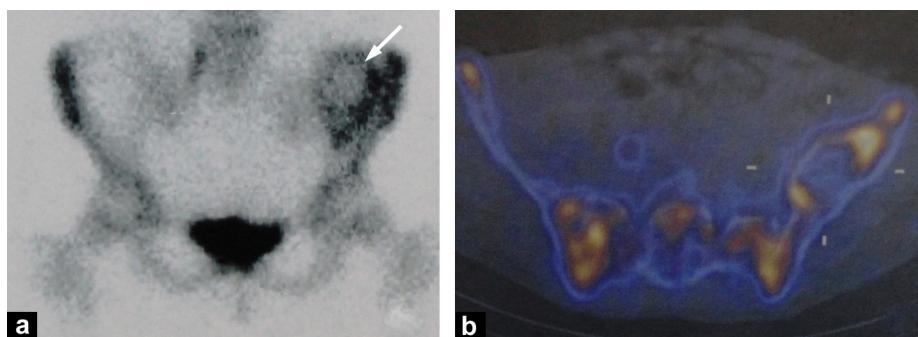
Bone scintigraphy (a) shows a peripheral rim of scintigraphic fixation surrounding a clear center ("doughnut sign", arrow). SPECT-CT (b) shows similar features with peripheral activity and central lucency.
